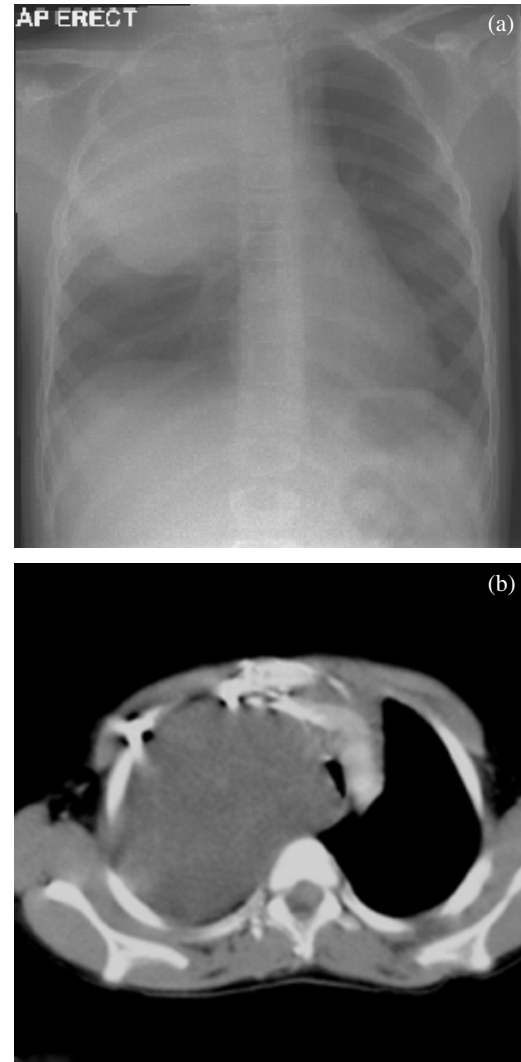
A 7-year-old child with stridor. (a) AP chest radiograph reveals a right upper lung zone opacity which causes compression and deviation of the trachea and deformity of the first two ribs posteriorly. (b) Axial CT of the thorax confirms the presence of a large intrathoracic lesion, proven to be ganglioneuroma.
